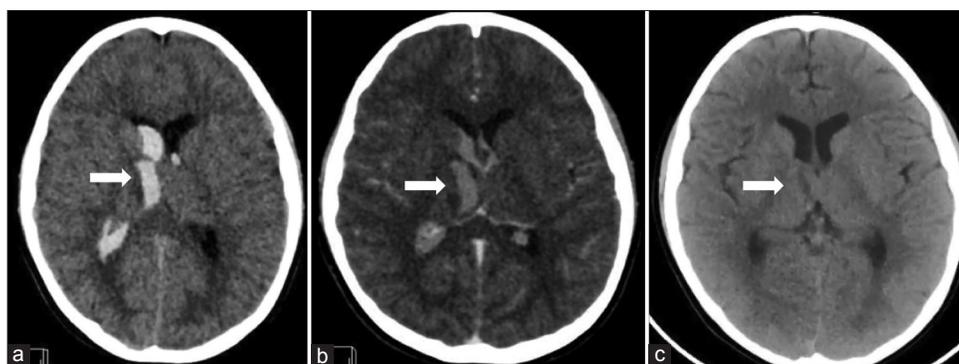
(a) Non-contrast brain computed tomography (CT) scan at admission showed a bleeding in the right anteromedial thalamus (arrow) and intraventricular hemorrhage. (b) Contrast-enhanced CT scan showed no evidence of abnormal enhancement in the right thalamus (arrow). (c) Before embolization, non-contrast CT scan showed encephalomalacia in the anteromedial portion of the right thalamus (arrow) with slight ventricular enlargement.
